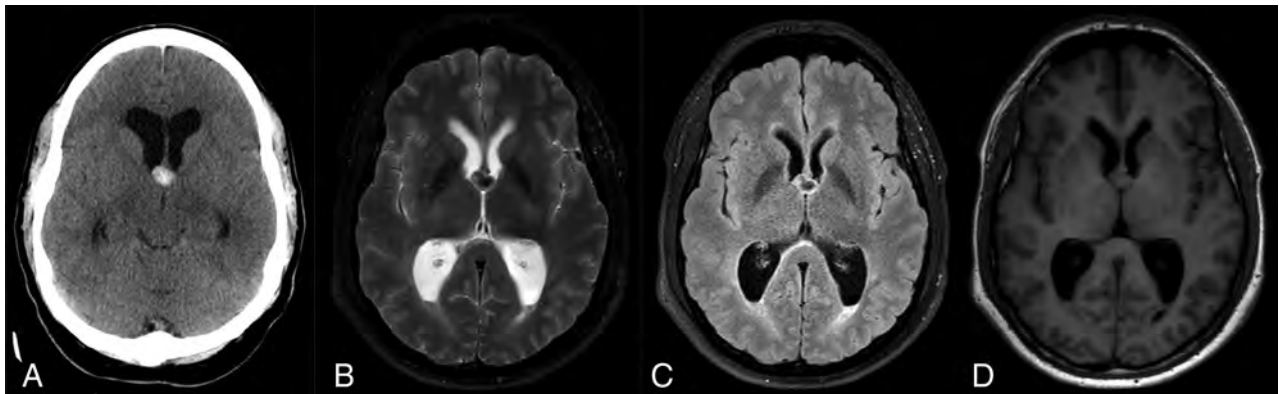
Cyst with rim: 55-year-old woman with a 6-week history of headache. Non-contrast CT (A) shows a hyperattenuated colloid cyst measuring 13 mm at the roof of third ventricle. On T2WI (B), the colloid cyst has a hypointense core with a thin hyperintense rim, which is more pronounced on T2-FLAIR (C). The cyst is mildly heterogeneous and isointense centrally on T1-weighted image (D). There was no evidence of hemorrhage on the GRE sequence (image not shown). There is associated enlargement of the lateral ventricles with periventricular edema.
